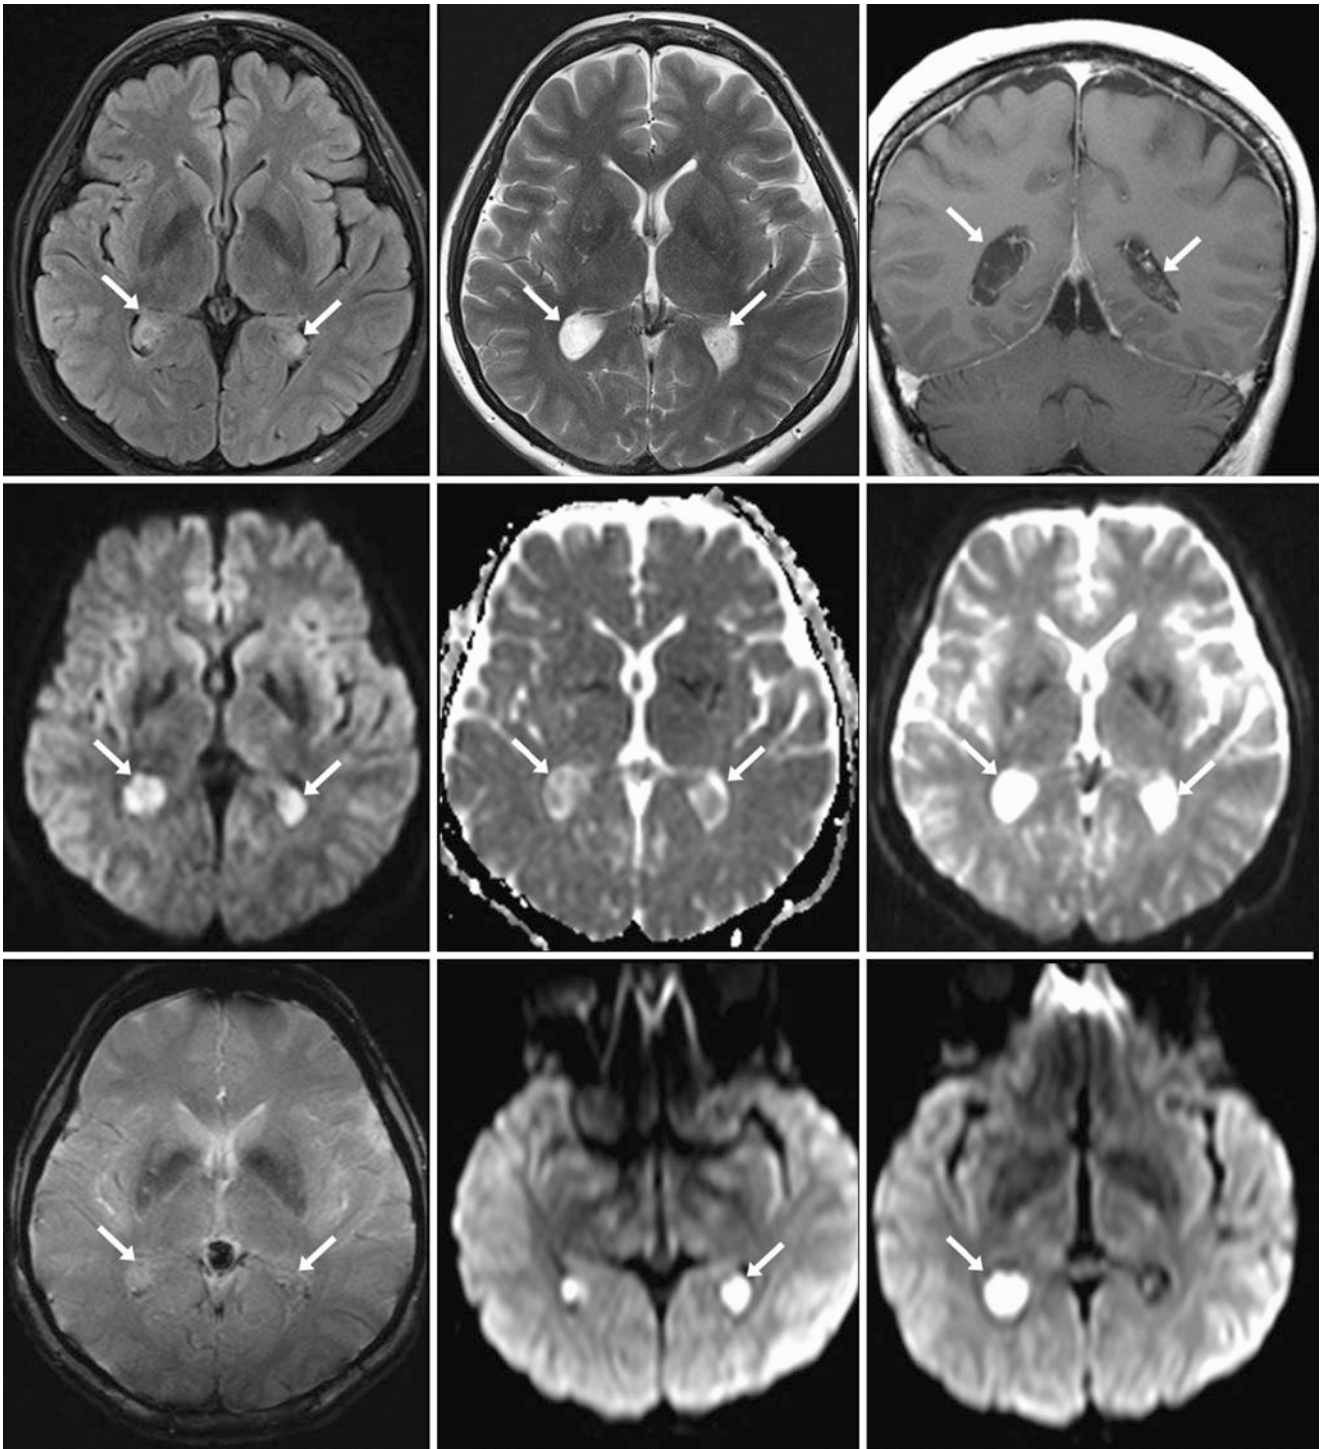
Choroid plexus xanthogranuloma (CPXG). A 48 year old underwent a 3 T MRI to rule out stroke (negative examination). *Top row*: there are bilateral CPXGs (*arrows*) within the atria of the lateral ventricles on FLAIR (*left*), T2WI (*middle*), and coronal postcontrast T1WI (*right*). *Middle row*: axial DWI with corresponding ADC maps (*left and middle images*) demonstrate bright and mildly dark signal, respectively. But why are the CPXGs brighter than the periventricular white matter on DWI if they are not darker than the white matter on the ADC maps? *Middle row*: The answer lies in evaluation of the “*b*=0”
